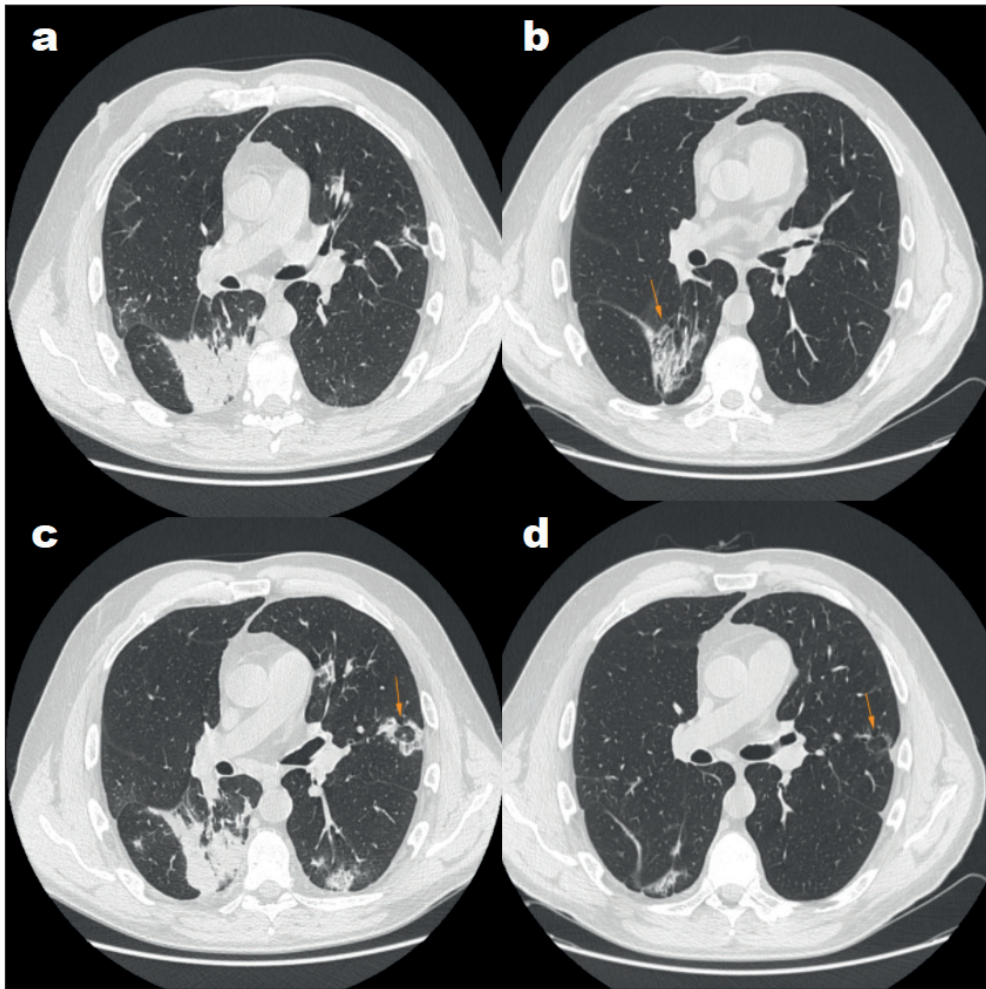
Patient 1. Corresponding CT changes seen at baseline (a, c) and after 146 days from onset (b, d). The regression of consolidations is observed with persistence of GGO, bronchiectasis and fibrosis. Red arrow shows the regression of the atoll sign and consolidations.
